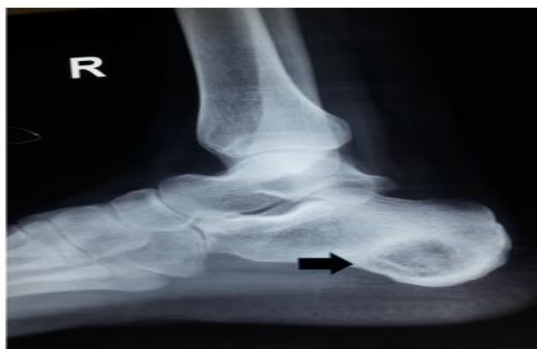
Lateral view radiograph of ankle before starting the treatment. Black arrow in the image showing a well-defined pure osseous lytic lesion in the body of calcaneum.
